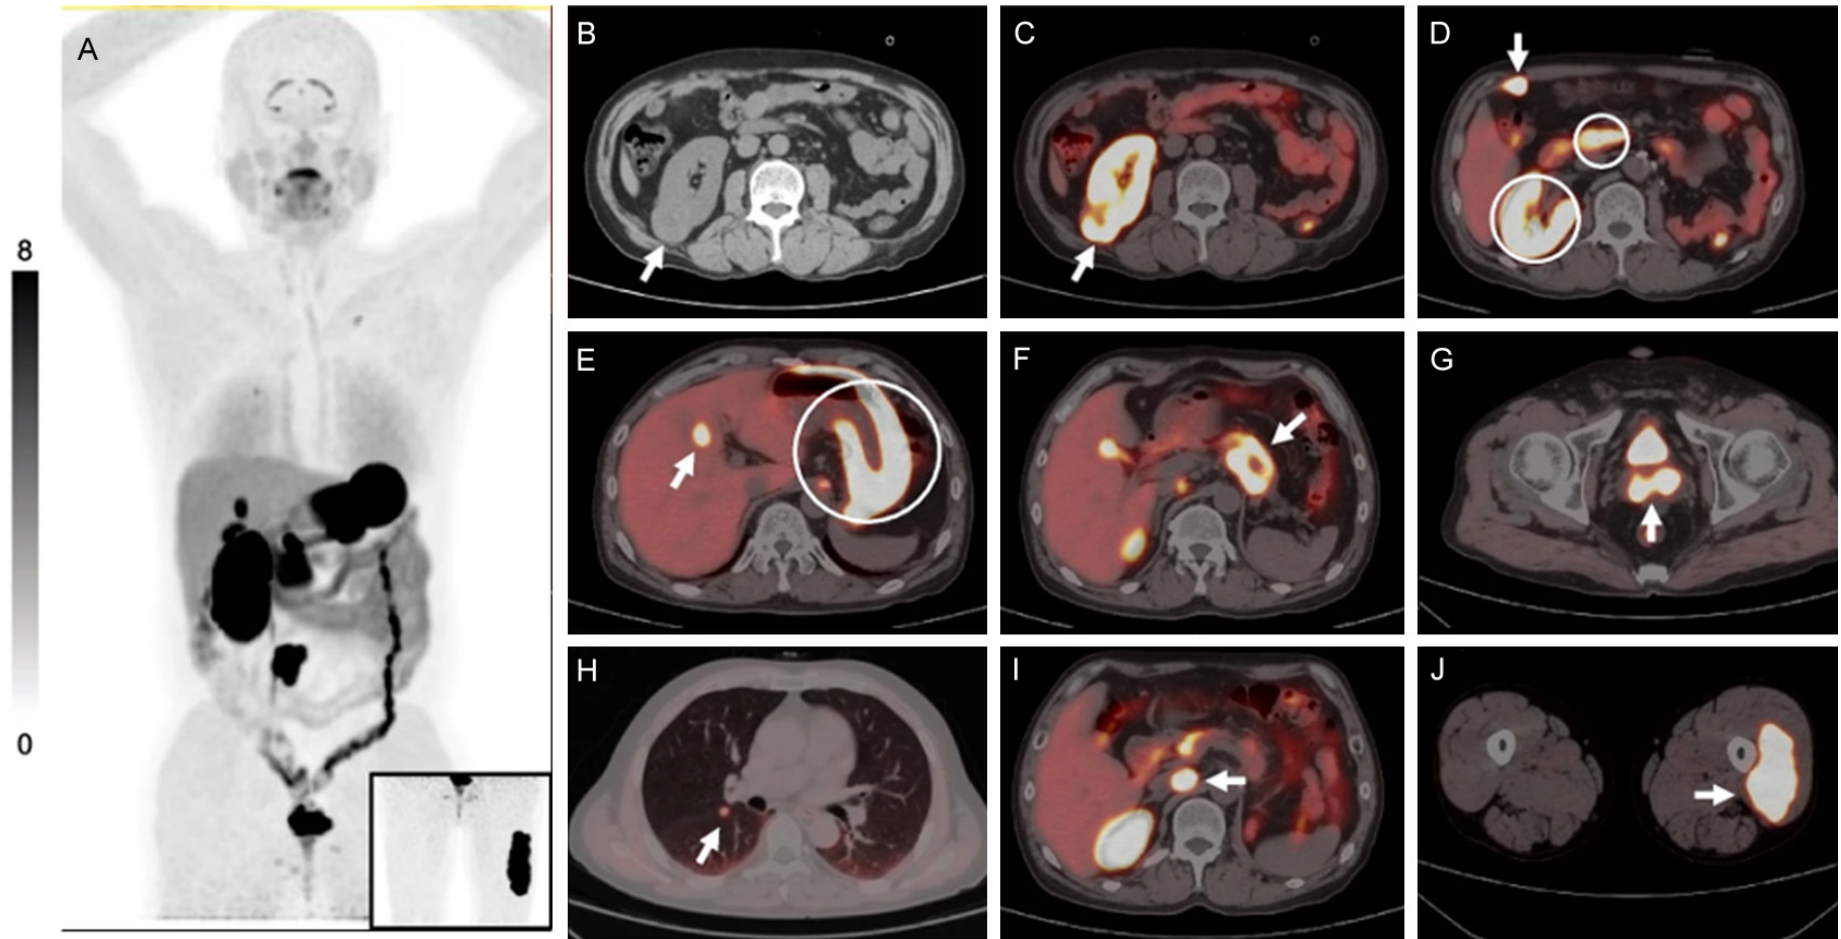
[^{68}Ga]Ga-NY104 PET/CT was performed for restaging in a 54-year-old male patient who had a history of radical nephrectomy due to left kidney ccRCC 14 years ago. All the lesions (A) were observed to be CAIX-overexpression, including the right kidney (B and C), abdominal wall (D), liver (E), pancreas (F), seminal vesicle (G), lung (H), paraaortic lymph node (I), and muscle of the left thigh (J) metastases (arrows). The abdominal wall lesion was confirmed to be metastasis from ccRCC by biopsy pathology. Note. The normal renal parenchyma, pancreas, and stomach wall showed intensive physiological uptake (circles in D and E). Mild physiologic uptake can also be observed in the lungs (A). Reprinted with permission from [13]. © EJNMMI.
